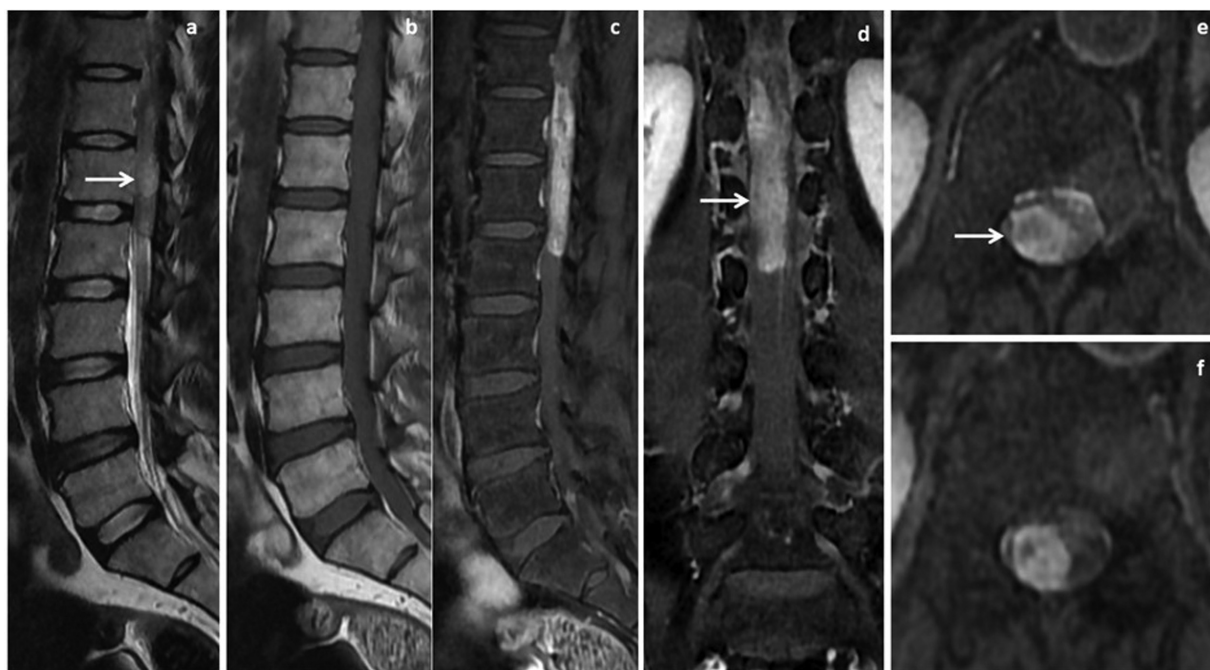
A 55-year-old female with intradural focal mass-like lymphoma presented with progressive paraparesis. Sagittal T2-weighted (T2W) and T1W (A and B) showed ill-defined T2 iso to slight hyperintense intradural focal mass-like lesion at D12 to L2 vertebral level (arrow). Sagittal, coronal, and axial postgadolinium T1W images (C–F) showed homogeneously enhancing plaque to mass-like lesion noted in intradural location displacing conus medullaris towards the left side (arrow).
